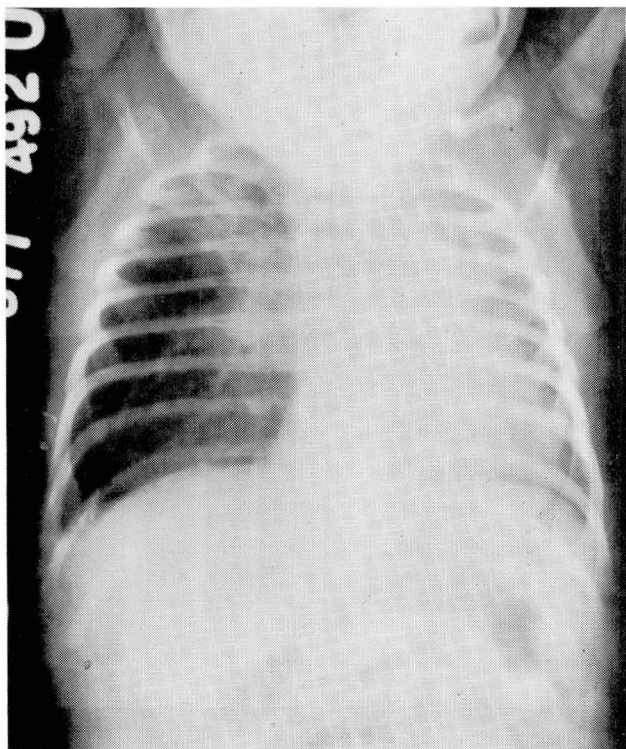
Case 2. Roentgenogram of the chest, demonstrating massive emphysema of the right middle lobe, and the heart displaced to the left.
